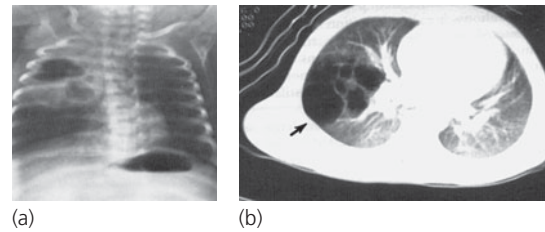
Chest radiograph and congenital cystic adenomatoid malformation of right upper lobe.
